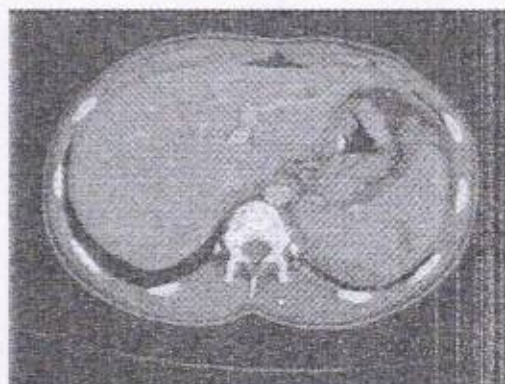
Contrast enhanced CT showing grade II splenic laceration.
